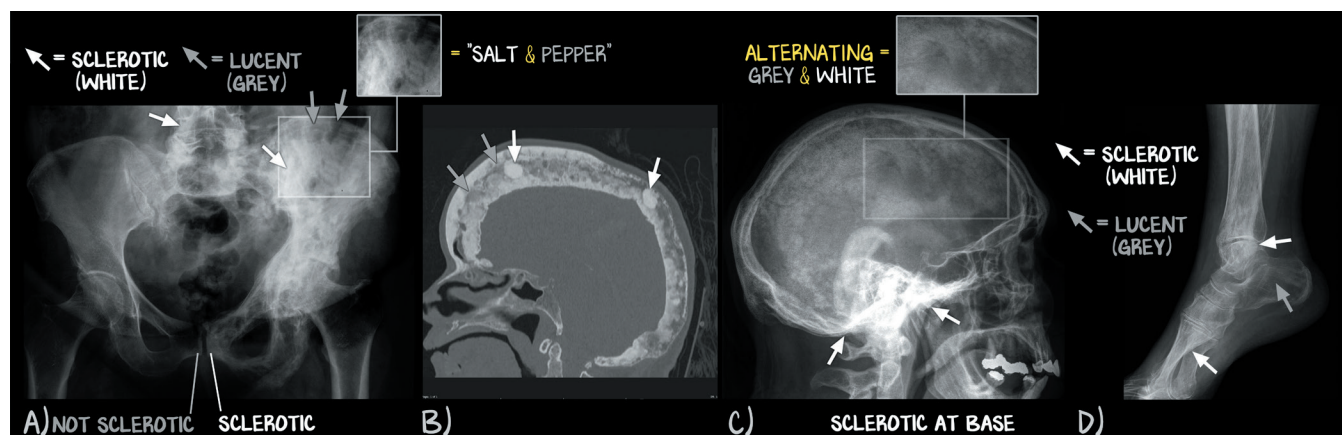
Radiographic Paget's Disease of Bone
